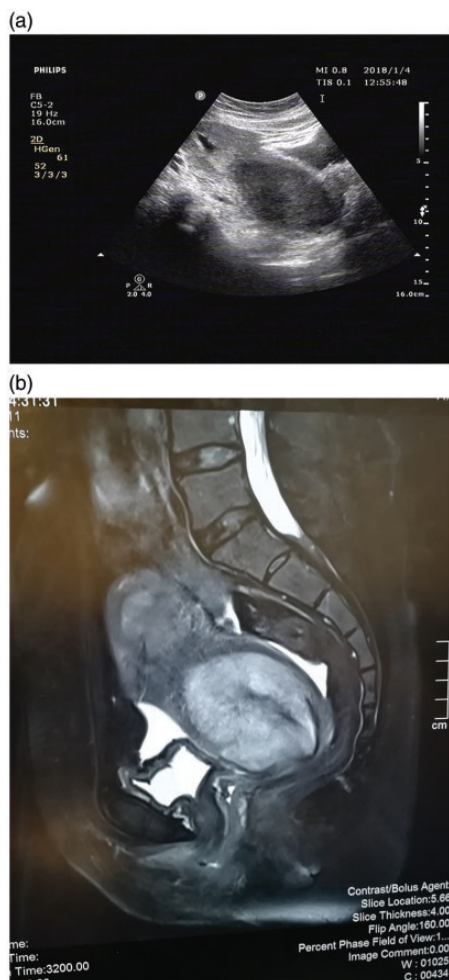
Imaging of the pelvis. (a) B-ultrasound of the pelvic cavity shows that there is a hyperechoic mass in the uterine cavity with a size of 27.4×12.9 mm. There is also a hypoechoic mass in the lower part of the uterine cavity with a size of 88.4×56.2 mm. (b) Magnetic resonance imaging of the pelvis shows a giant solid mass in the uterine cavity and cervix. Endometrial cancer (International Federation of Gynecology and Obstetrics stage II) accompanied by multiple lymph node metastasis in the bilateral iliac vessels was considered.
